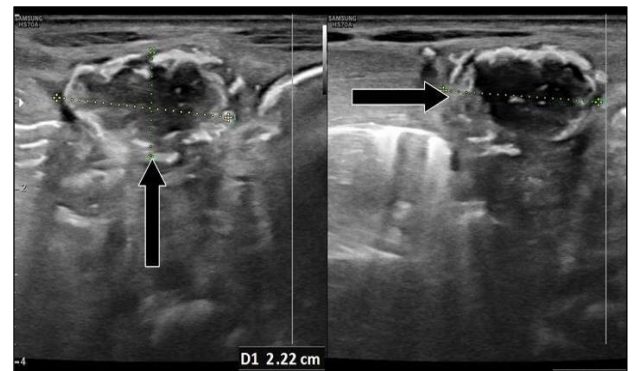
High Frequency transducer images of sonography calcified lesion with posterior acoustic shadowing, which is seen separate from the gut which is air filled.
